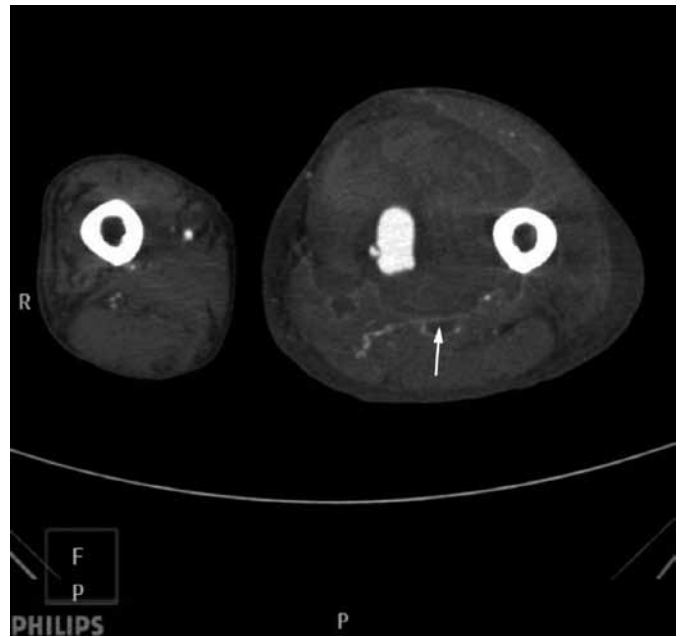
Axial CT of femur showing small ring-enhancing pockets coming from the huge haematoma.
